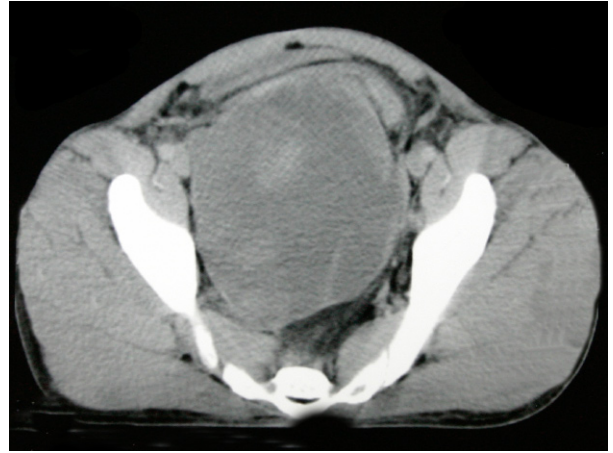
CT showing enormous augments in pelvic mass that provoked ureteral and colonic obstruction
